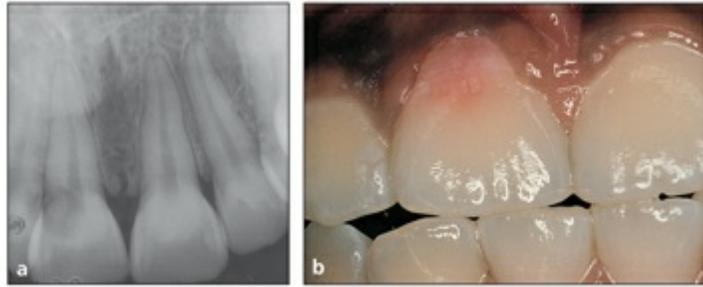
(a) Radiographic appearance of a maxillary incisor with external root resorption extending coronally. Note the outline of the root canal through the resorptive radiolucency. (b) The clinical appearance shows a pink spot close to the gingival margin on the labial surface of the tooth.
